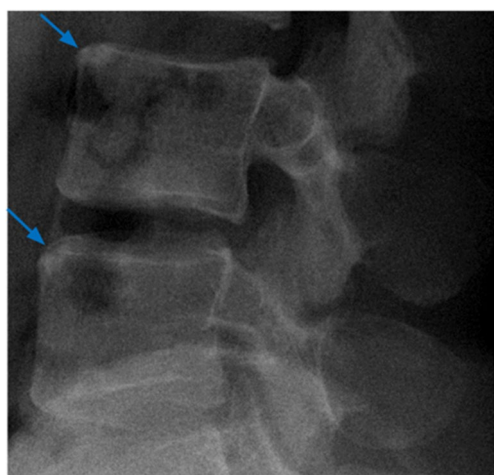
A 41-year-old with psoriatic arthritis. Lateral radiograph of the lumbar region demonstrates Romanus lesions, appearing as bone erosions involving the anterior edges of the vertebral endplates with reactive sclerosis ("shiny corners")
